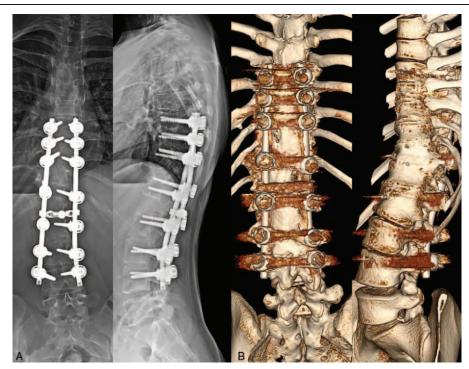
(A) Eleven-year follow-up radiographs after PVCR showing the main scoliotic curve well maintained at 20° and distal compensatory curve at 9°. (B) Elevenyear follow-up 3D reconstruction computed tomography scan after PVCR. PVCR = posterior vertebral column resection.
